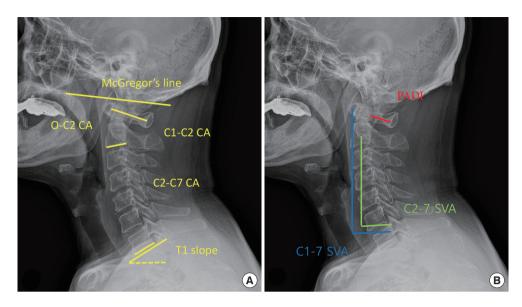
Radiologic parameters on a cervical lateral plain radiograph in patient with atlantoaxial dislocation. (A) O–C2, C1–2, C1–7, C2–7, T1 slope are measured between the lines on cervical lateral plain radiograph. (B) C1–7 (blue line), C2–C7 sagittal vertical axis (SVA; green line), and posterior atlantodental interval (PADI; red line) are measured on cervical lateral plain radiograph. CA, cobb angle.
